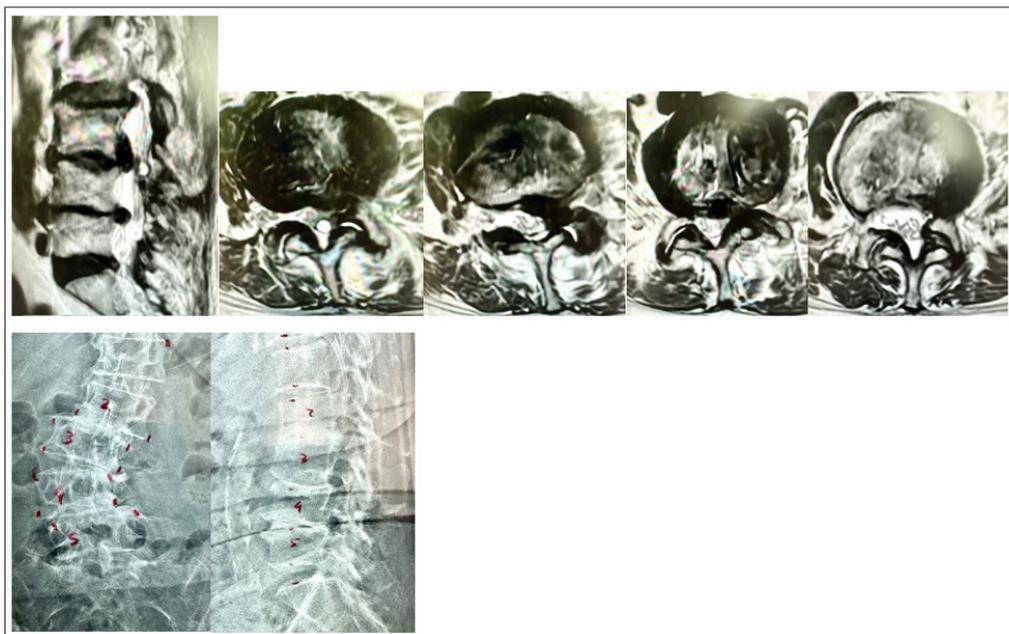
MRI before and after Endoscopic Surgery
